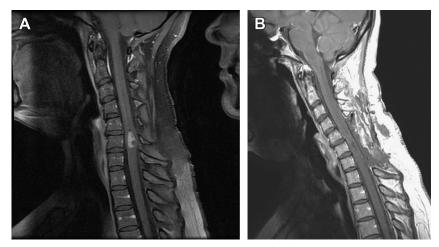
(*A*) Preoperative sagittal T1-weighted magnetic resonance (MR) image with gadolinium, showing characteristics of an intramedullary ependymoma. (*B*) Postoperative sagittal T1-weighted MR image with gadolinium, showing complete resection of ependymoma with associated postoperative changes.
